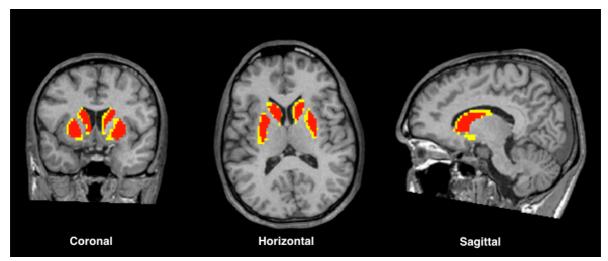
Color coded pixels extracted from Regions of interests (ROI's) of the striatum, superimposed on MRI images. Three orthogonal projections show pixels from manual (red) superimposed on automated (yellow) generated ROI's.
